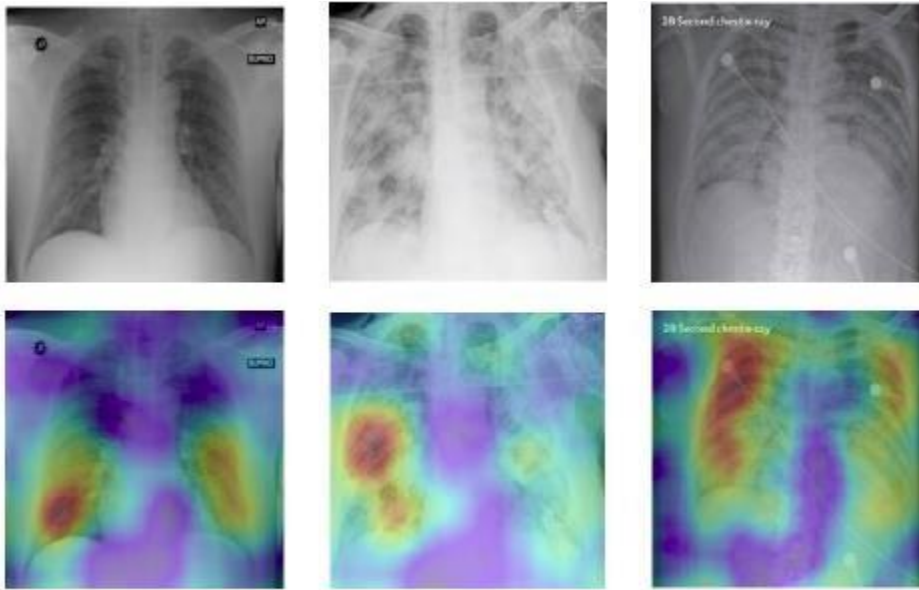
Saliency map visaulization over COVID-19 positive X-Rays.
